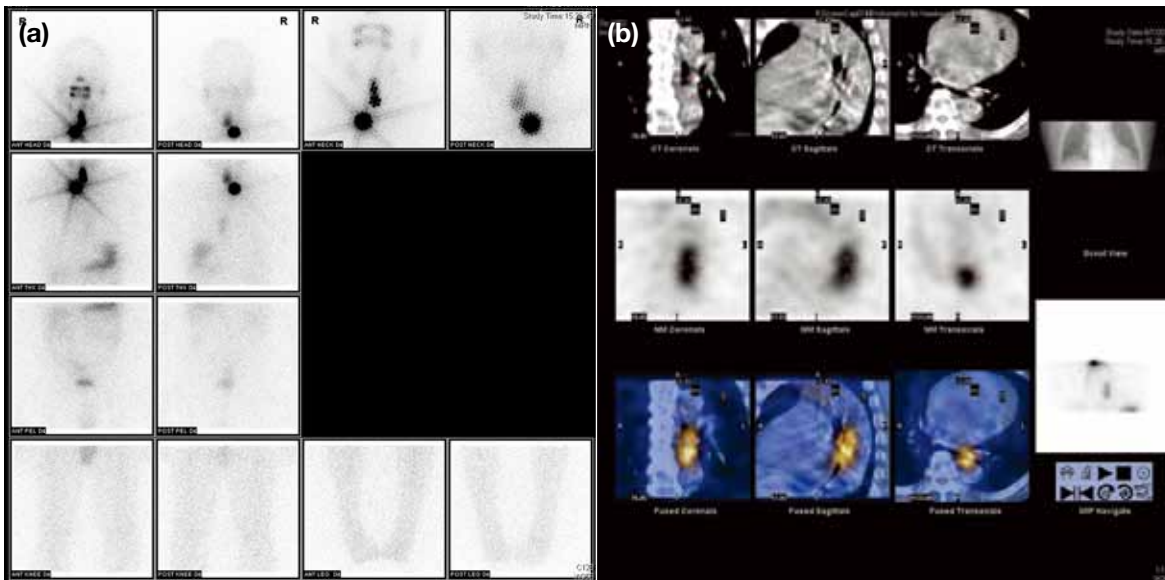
(a) High-dose localised planar views show intense activity in the neck suggestive of local residual malignancy with equivocal uptake in the chest. (b) ^{131}I SPECT/CT fusion images show that the activity was localised to the posterior mediastinum in the region of the mid-oesophagus, and was suspicious for metastasis.
